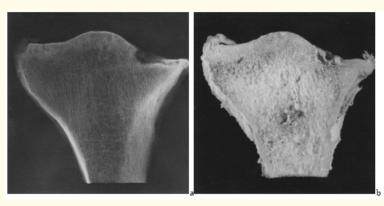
RA, knee joint, purulent arthritis. (a) Latero-lateral X-Ray photograph, (b) Postero-anterior X-Ray photograph.
